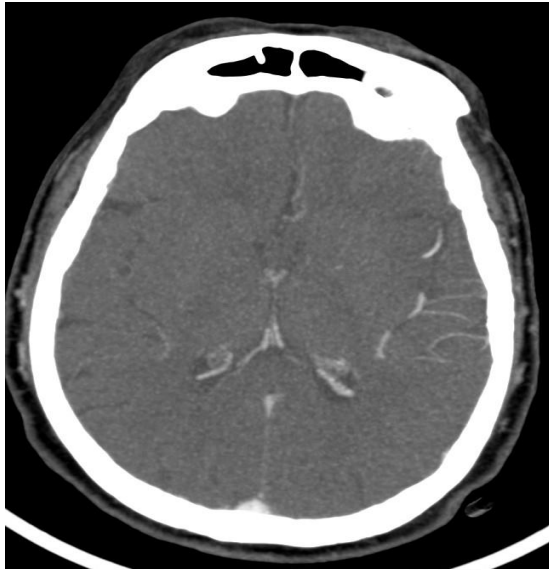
Axial CT MIP Art. Del. phase showing Poor collateral score (mASITN/SIR 1)
